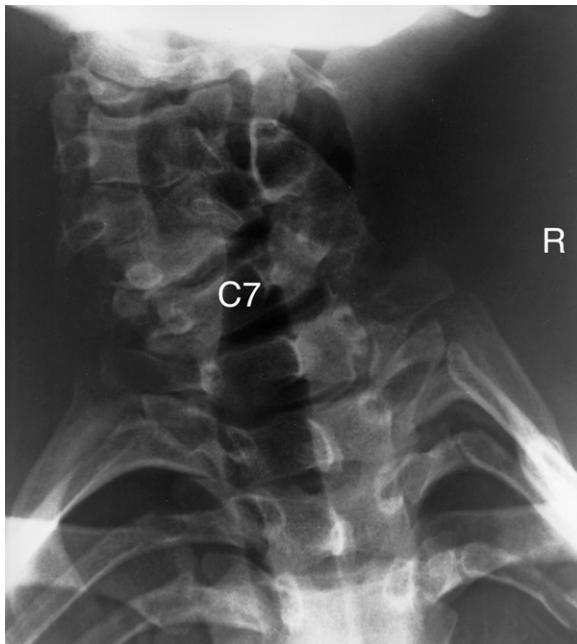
Cervical spine anteroposterior plain X-ray image viewed from behind. Note the left convex cervical spine scoliosis with some hemivertebrae.
